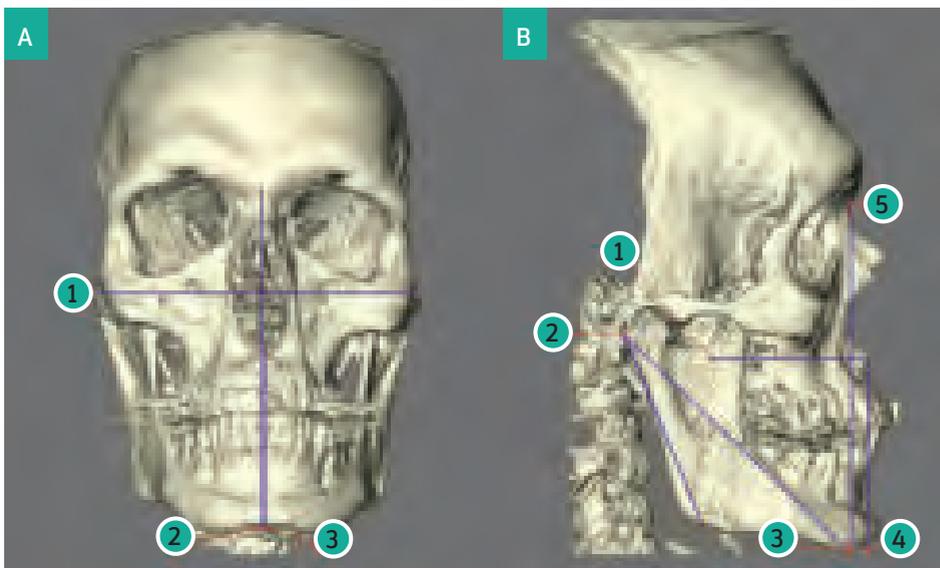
3D cone beam CT scan of the skull of one of the patients in remission of acromegaly. The projected lines depict the hard tissue measurements that differ between patients and controls.
